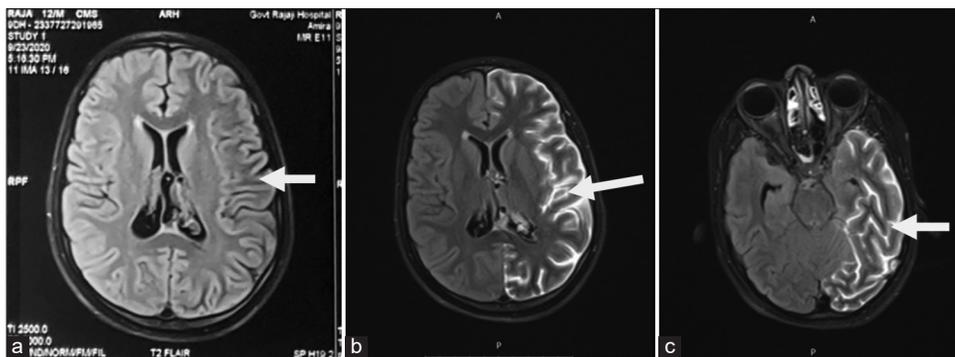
(a) Magnetic resonance imaging T2 FLAIR shows atrophy of cortex. (b and c) Magnetic resonance imaging T2 post contrast FLAIR shows left frontotemporoparietooccipital pial enhancement
